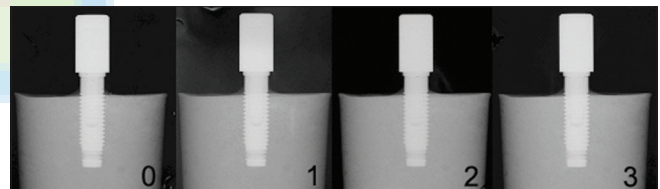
X-ray of a sample: 0 = before fatigue tests, 1 = after the first cycle, 2 = after the second cycle, 3 = after the third cycle
